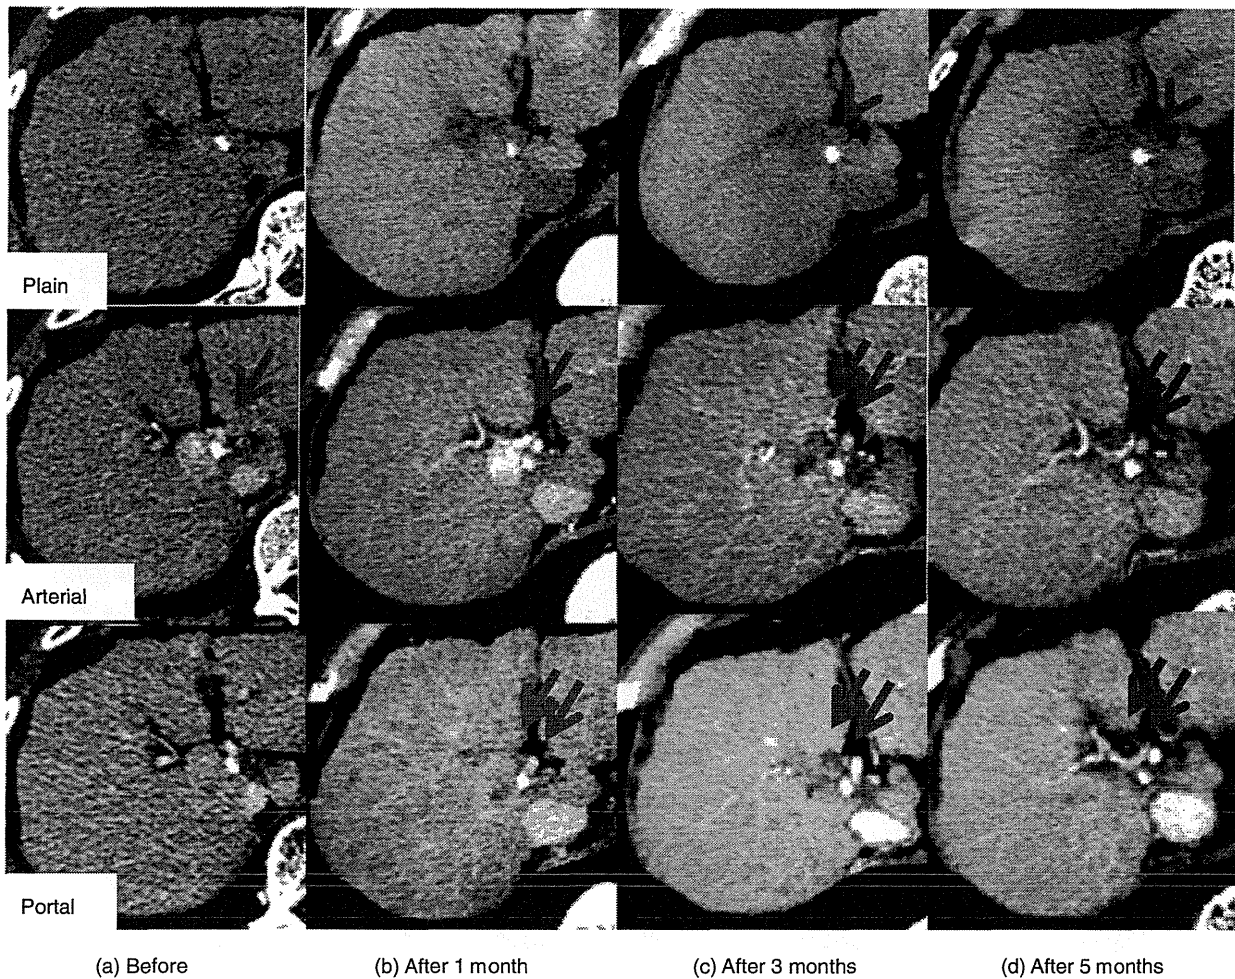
Dynamic computed tomography appearance of tumor response type 2 (plain, arterial and portal phase in case 9). (a) Before stereotactic body radiation therapy (SBRT); early arterial enhancement and partial residual lipiodol were observed (red arrow). (b) One month after SBRT, early arterial enhancement was still present (red arrow). Hypodensity of this tumor changed in the portal venous phase (two red arrows). (c) Three and (d) 5 months after SBRT, early arterial enhancement was no longer evident and hypodensity changed (two red arrows). Residual lipiodol accumulation is still noted (red arrow head).
